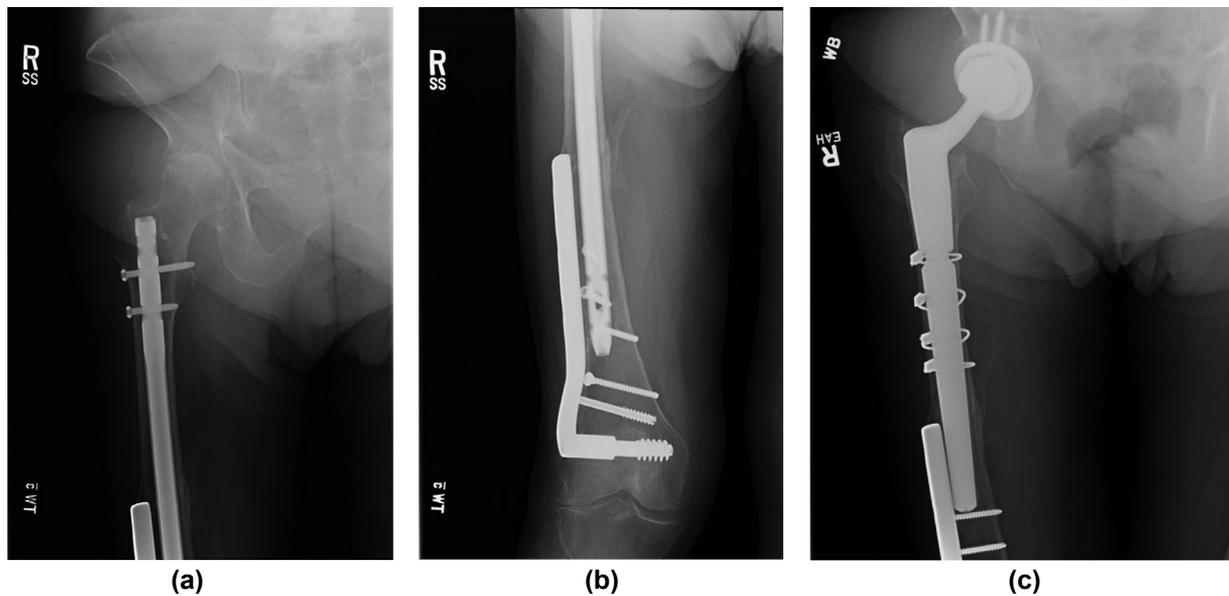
(a-c) 87-year-old female status post multiple fracture to her right femur, now with end stage arthritis of right hip. The femur has an intramedullary nail and blade plate distally. Through a direct lateral approach, the nail is removed. A total hip arthroplasty is performed but is complicated by periprosthetic femur fracture due to poor bone quality. This was repaired with several cerclage cables. Ultimately did well with partial weight bearing for 8 weeks. Post-op radiographs are 1 year following surgery.
